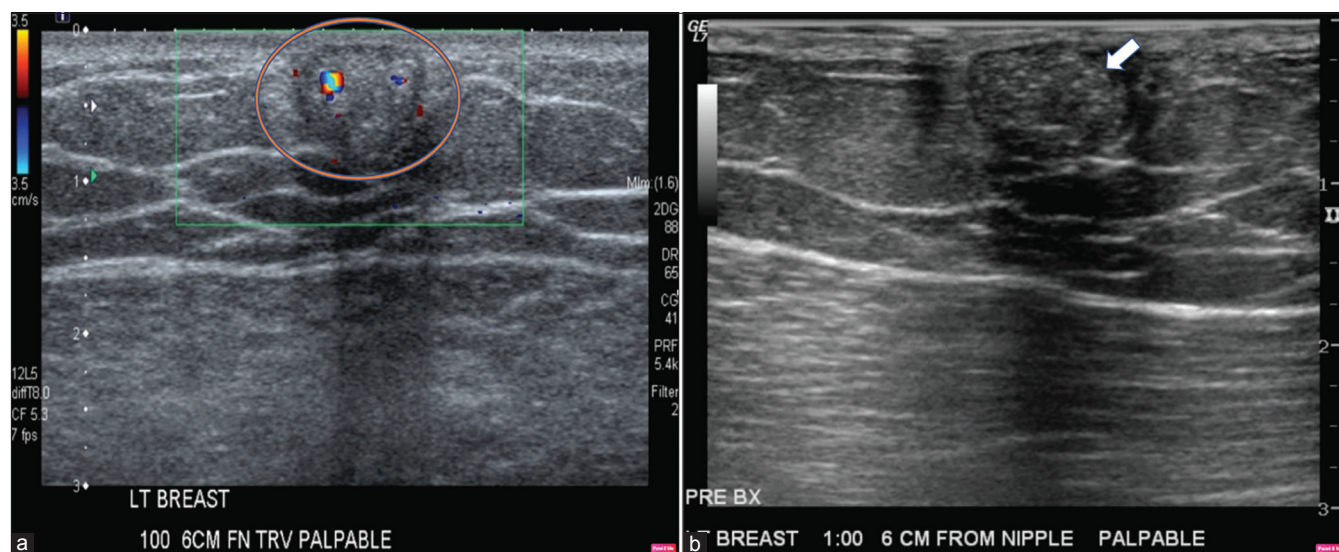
A 36-year-old HIV positive male presented with a painless hard palpable “pea-size” lump in the left breast, upper outer quadrant, present for many years, increased in size over the most recent 6 months. (a) A color doppler ultrasound image of the lesion shows internal vascularity. (b) A grayscale ultrasound image pre-biopsy better demonstrating the small hyperechoic foci of calcifications (white arrow) observed on the mammogram.
